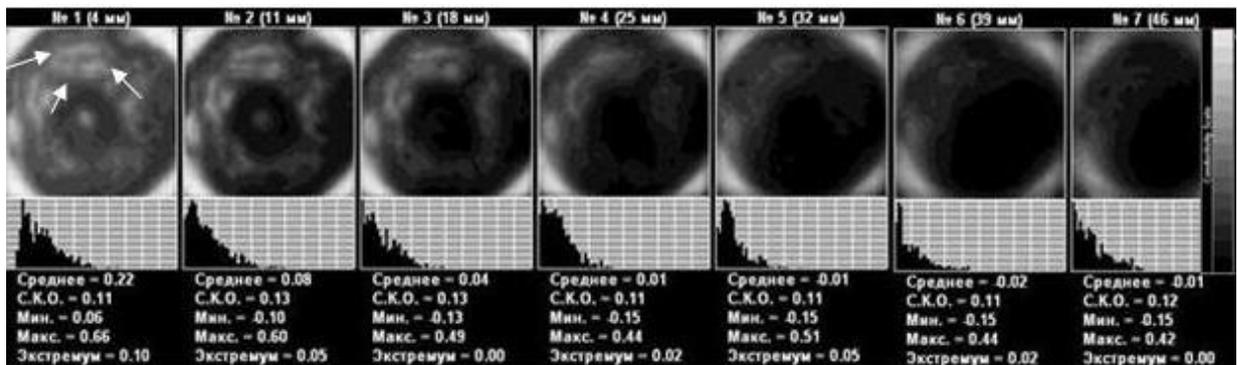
EIM. In the upper segment there is a well-contoured isoimpedance formation measuring 41x27 mm with a hyper-impedance contour. Ultrasound: in the upper segment there is an iso-echoic structure in the capsule with septa (sized 36x29 mm).
